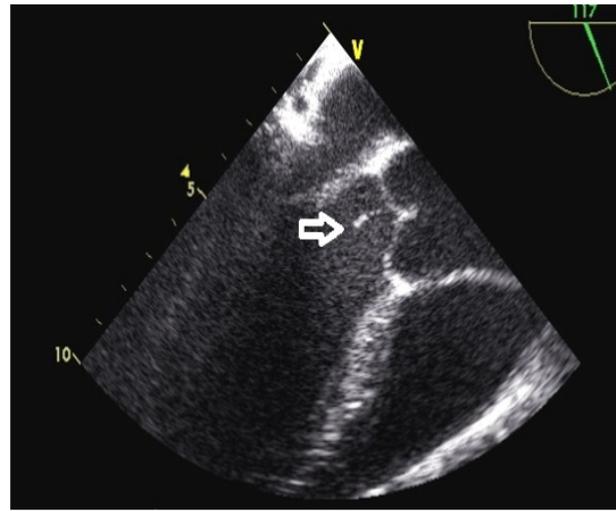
Transesophageal echocardiogram (TEE) showing a small excrescences on the aortic valve protruding into the as-cending aorta
